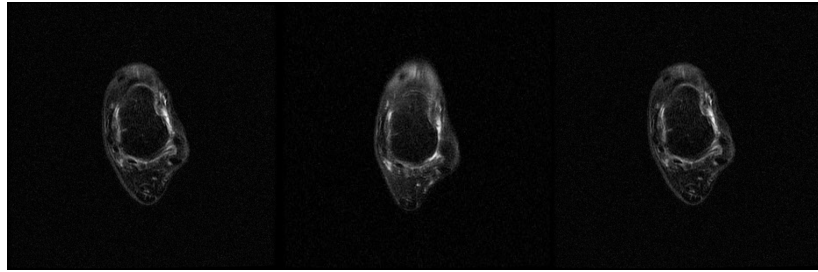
MRI showing injury to the anterior talofibular ligament
